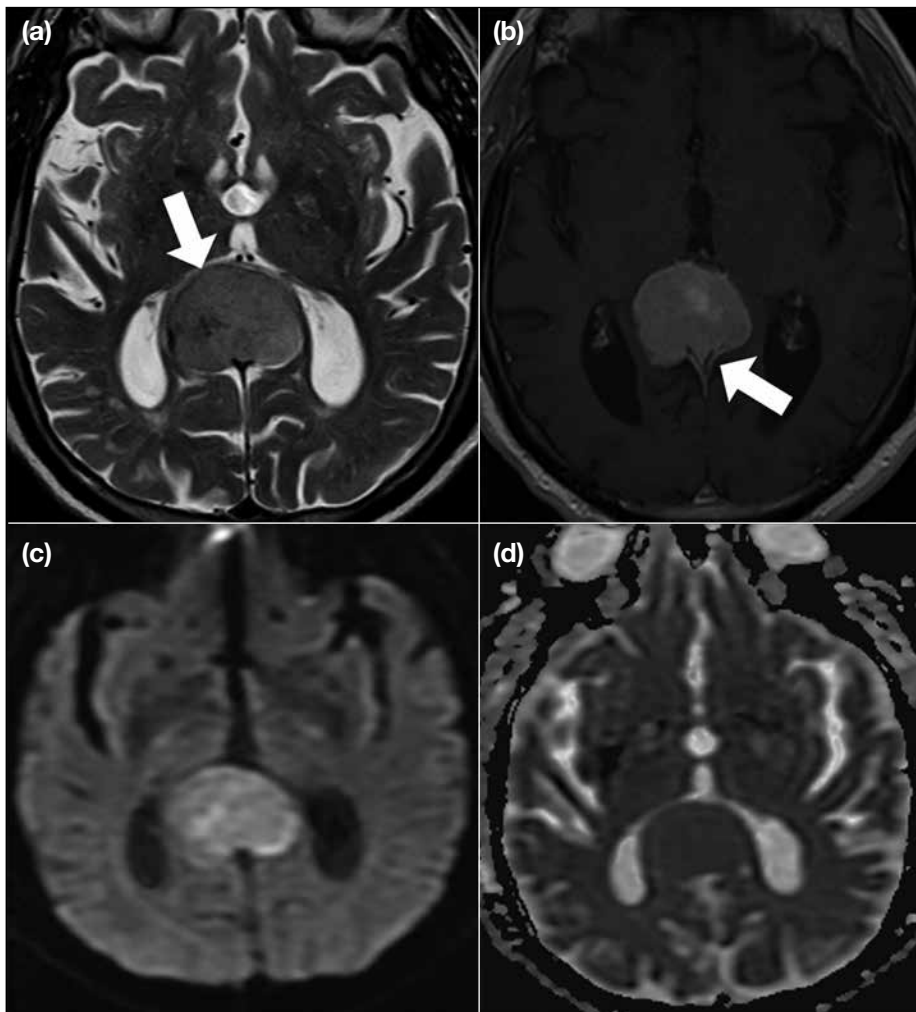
Meningioma. There is a well-defined hyperintense tumour (arrow) with minimal hypointensity on T2-weighted image in the pineal region (a). Strong enhancement with a small dural tail (arrow) is found on enhanced axial T1-weighted image (b). Mild water restriction is noted on diffusion-weighted imaging (c) and apparent diffusion coefficient image (d).
